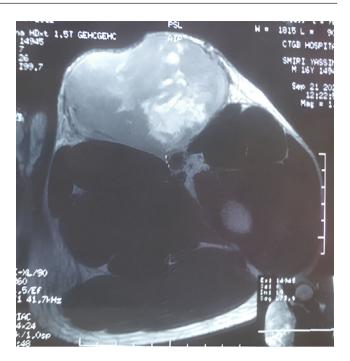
Axial section of the MRI of the left thigh, showing a well-limited subcutaneous mass on the anterior side of the proximal thigh, intensely enhanced after gadolinium injection. It displaces the anterior thigh muscles and comes into contact with the femoral vascular pedicle.
